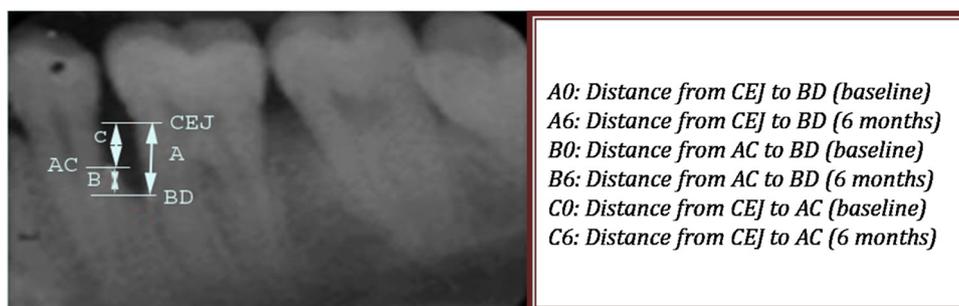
The radiographic parameters depicted in figure were recorded at baseline and 6 months post treatment.
